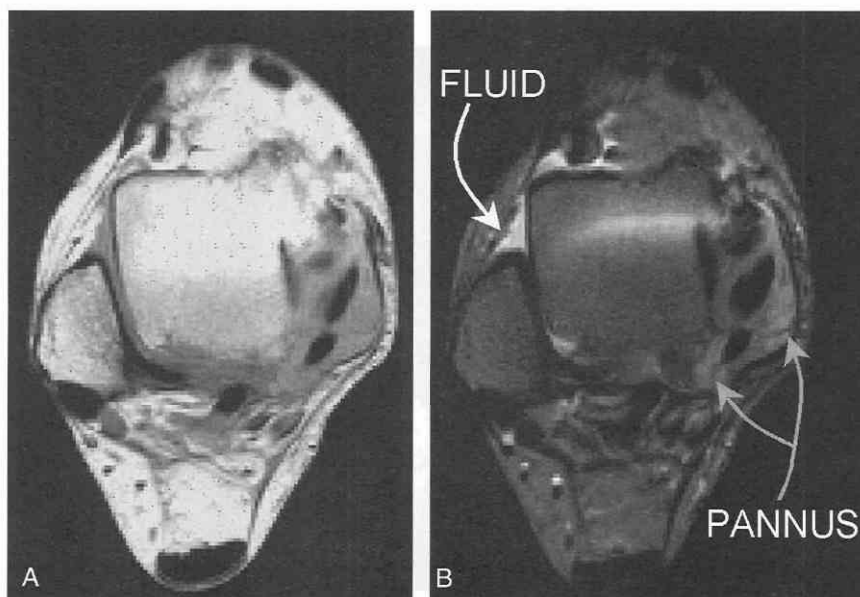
Rheumatoid arthritis and diffuse medial ankle pain in a 51-year-old woman. Axial proton-density-weighted (*A*) and T2-weighted (*B*) images reveal abnormal signal around both the posterior tibial and flexor digitorum longus tendons. However, this signal is not as bright as the normal fluid in the ankle joint (*white arrow*) and represents rheumatoid pannus (*gray arrows*). The patient remained pain-free for 1 year following a therapeutic tenogram.
